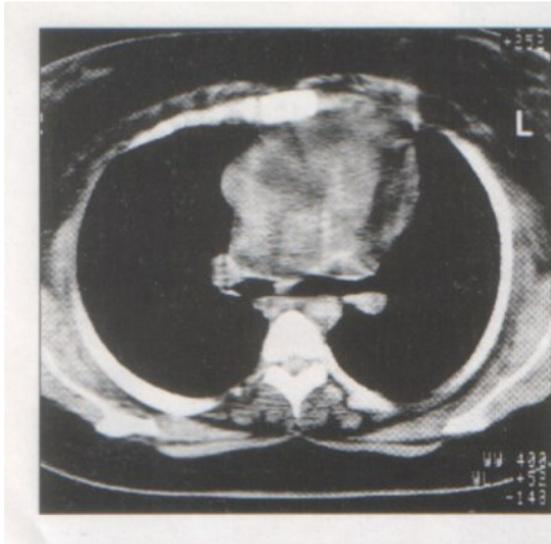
CT scan of thorax on admission.
